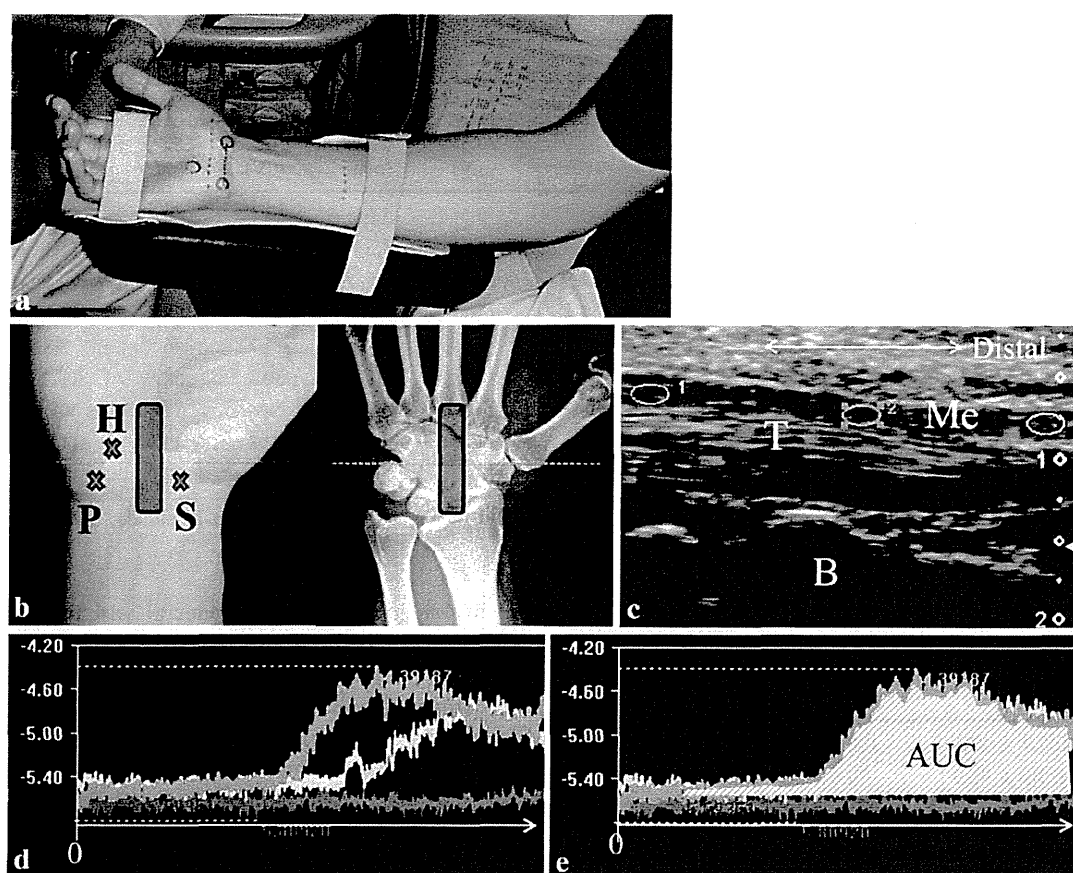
a Patient's forearm position during the ultrasound study. Scaphoid tubercle, pisiform, and hook of hamate were marked on the skin surface by palpation. b The probe position was determined to be at the center of the scaphoid tubercle–pisiform line and hook of hamate, and a scan of the median nerve long axis view was performed. *H* hook of hamate; *P* pisiform; *S* scaphoid tubercle. c B-mode ultrasonography of median nerve long axis view. ROIs are
